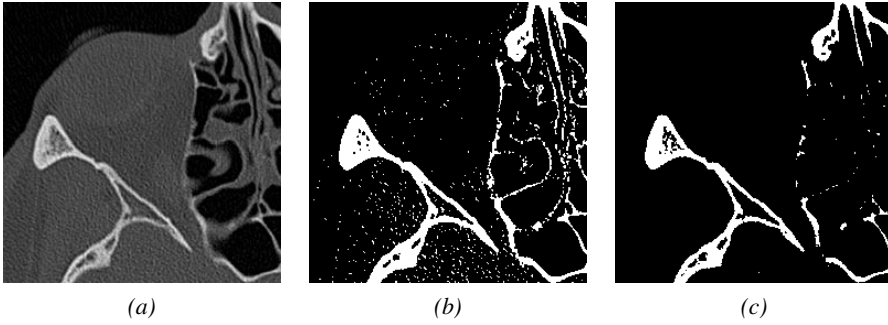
Global thresholding of thin orbital bone structures in a grayscale CT image: (a) original image; (b) thresholding result for $t = 200$ HU; (c) thresholding result for $t = 400$ HU.
